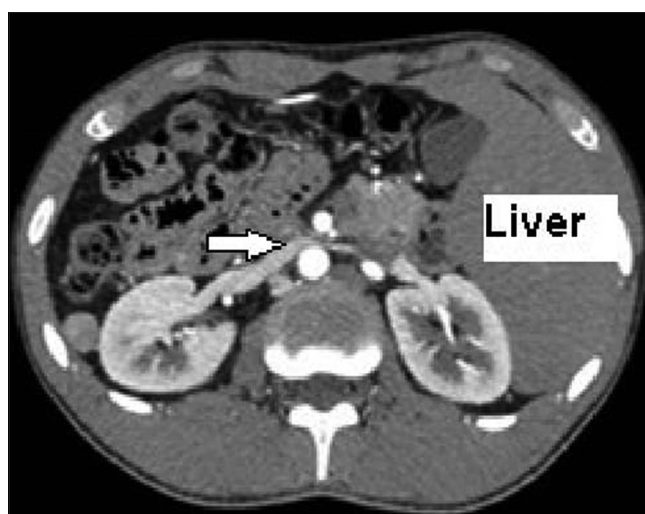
In this cross- sectional computed tomography image, the right renal vein is longer and complete transposition of abdominal organs including great vessels is appreciated
